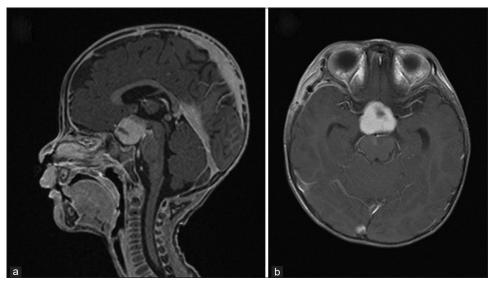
Magnetic resonance imaging in a 14-month-old male showing a gadolinium-enhanced tumour in the suprasellar and hypothalamic regions in (a) sagittal and (b) transverse views.
